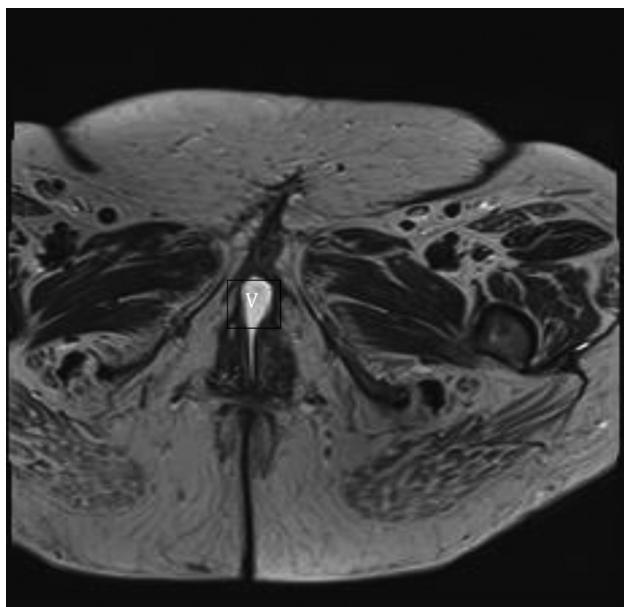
Axial T2-weighted image 26 months after surgery showing continued healing in operative bed. V: gel in vaginal opening.
